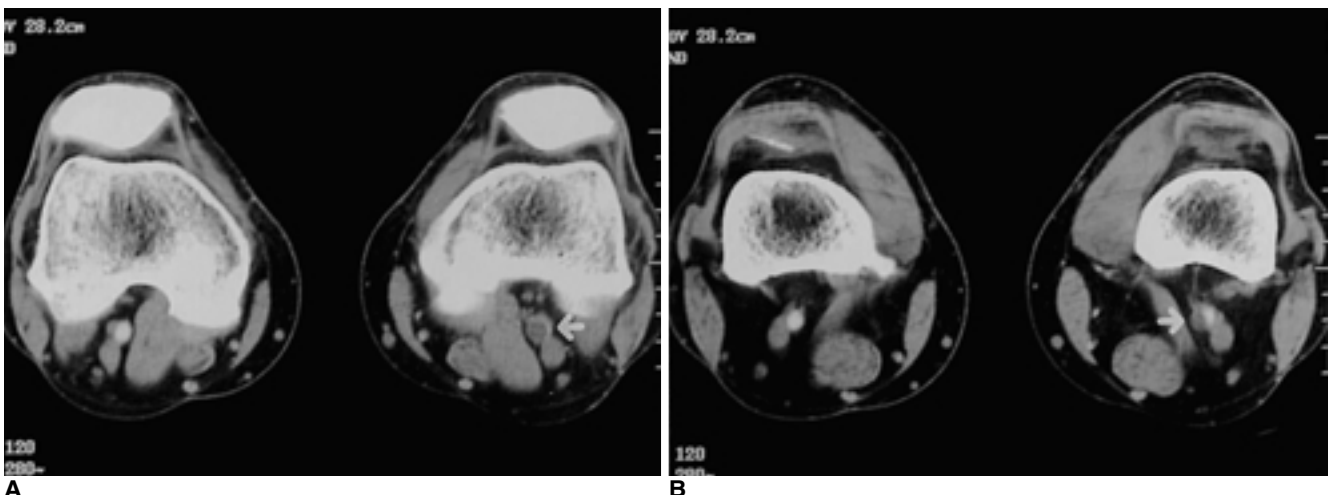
A. Contrast-enhanced axial CT scan through the upper popliteal fossa shows cystic mass abutting on the left popliteal artery (arrow).
